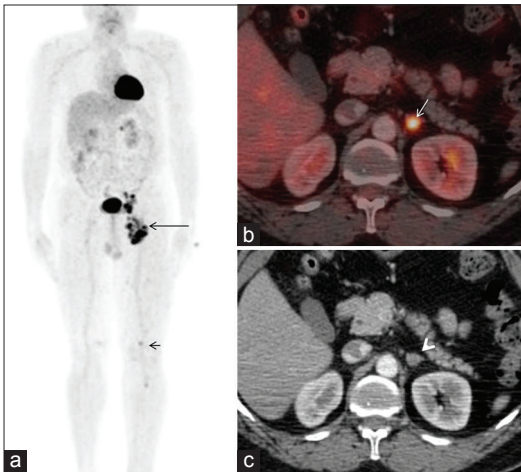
A 59-year-old male with primary melanoma in the left foot with clinically palpable regional nodes in the left groin. Maximum intensity projection image (a) shows increased fluorodeoxyglucose uptake in the enlarged left inguofemoral nodes (thin black arrow) and left popliteal fossa. (b) Fused positron emission tomography/computed tomography images show solitary focus of increased fluorodeoxyglucose uptake involving a nodule in the left adrenal gland (thin white arrow), which was equivocal for disease by computed tomography criteria (arrowhead). Positive metastatic disease was proven by computed tomography-guided biopsy of the adrenal node. This case supports the recommendation of using positron emission tomography/computed tomography in patients with clinically palpable regional nodal disease (i.e., Stage III B/C) with high incidence of clinically occult metastatic disease
